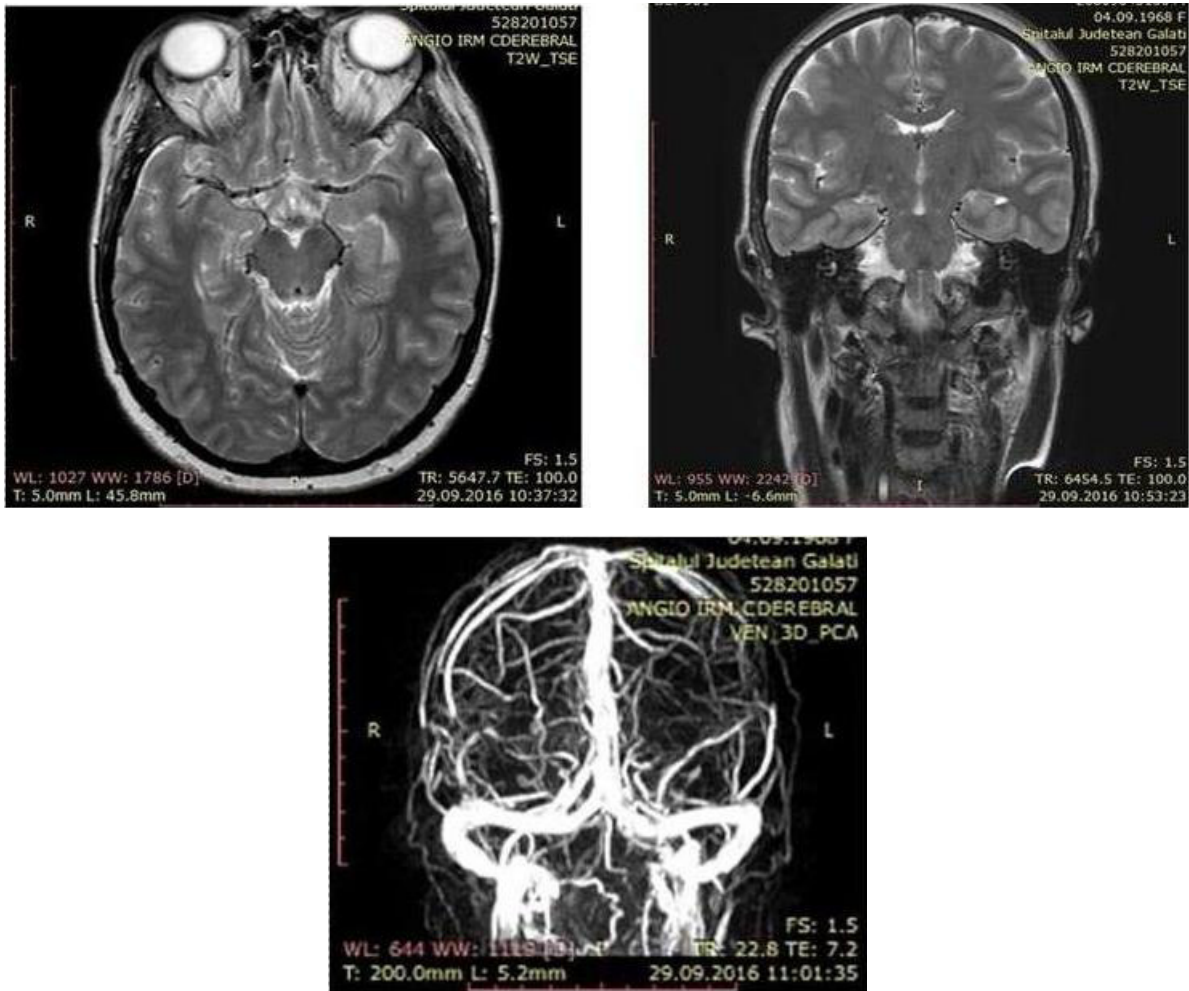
Brain MRI and angiMRI does not reveal any pathological changes that can explain the super-refractory status epilepticus
